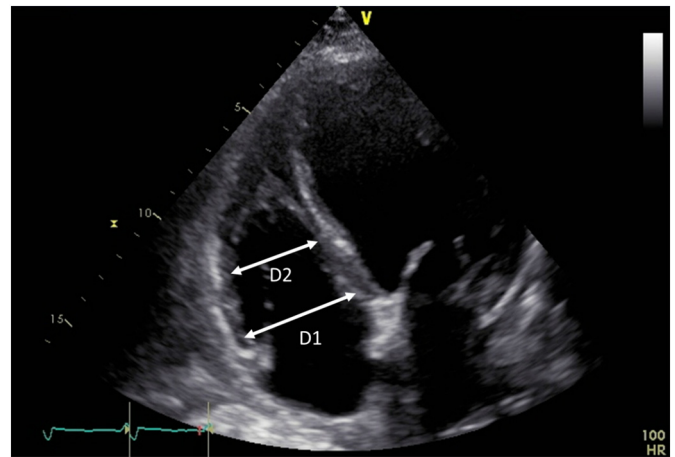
Echocardiographic assessment of RV dimensions from a, RV-focused apical four-chamber view. D1 = maximum transverse dimension during the basal one-third of RV inflow at end diastole D2 = transverse dimension during the middle third of RV inflow at end diastole. RV, right ventricular.
